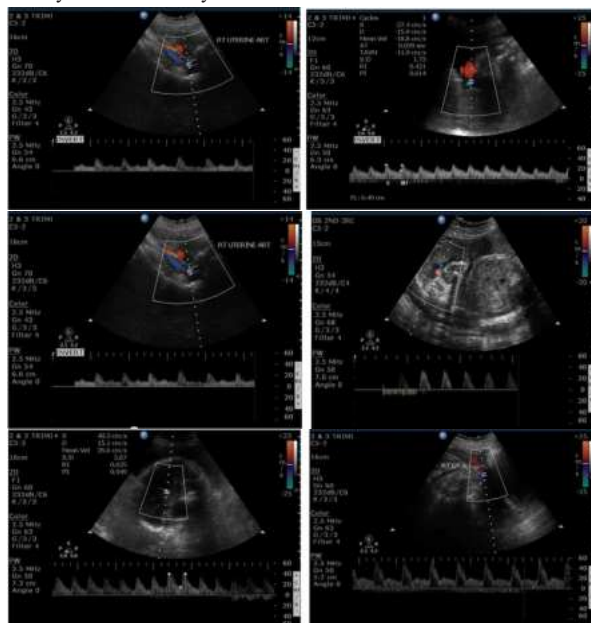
Uterine artery showing normal wave forms and velocimetry, Fig No.2 Umbilical artery showing normal wave forms and velocimetry, Fig No.3 Middle cerebral artery showing normal waveforms and velocimetry, Fig No.4 Uterine artery Doppler showing early diastolic notch, with high S/D, Fig No.5 Uterine artery with diastolic notch, Fig No.6 Umbilical artery with reduced diastolic flow.
